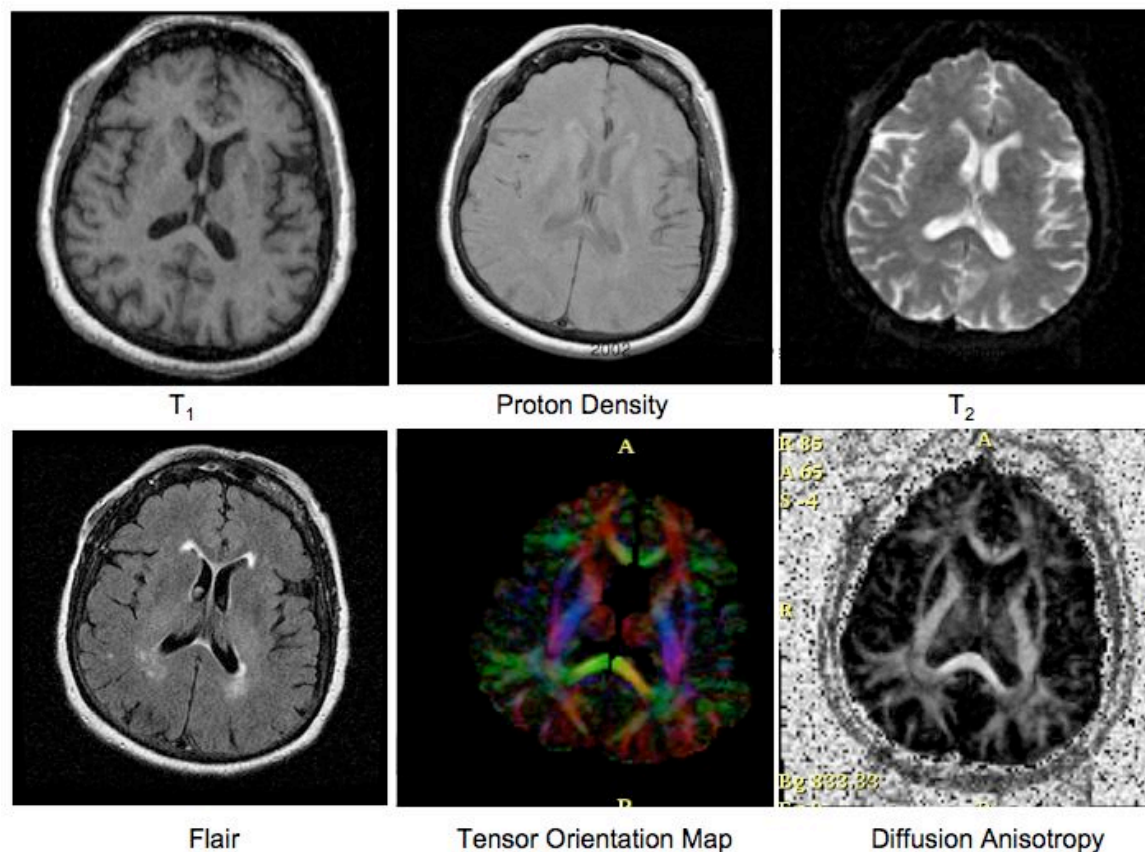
A variety of types of MR images can be acquired for brain imaging.
